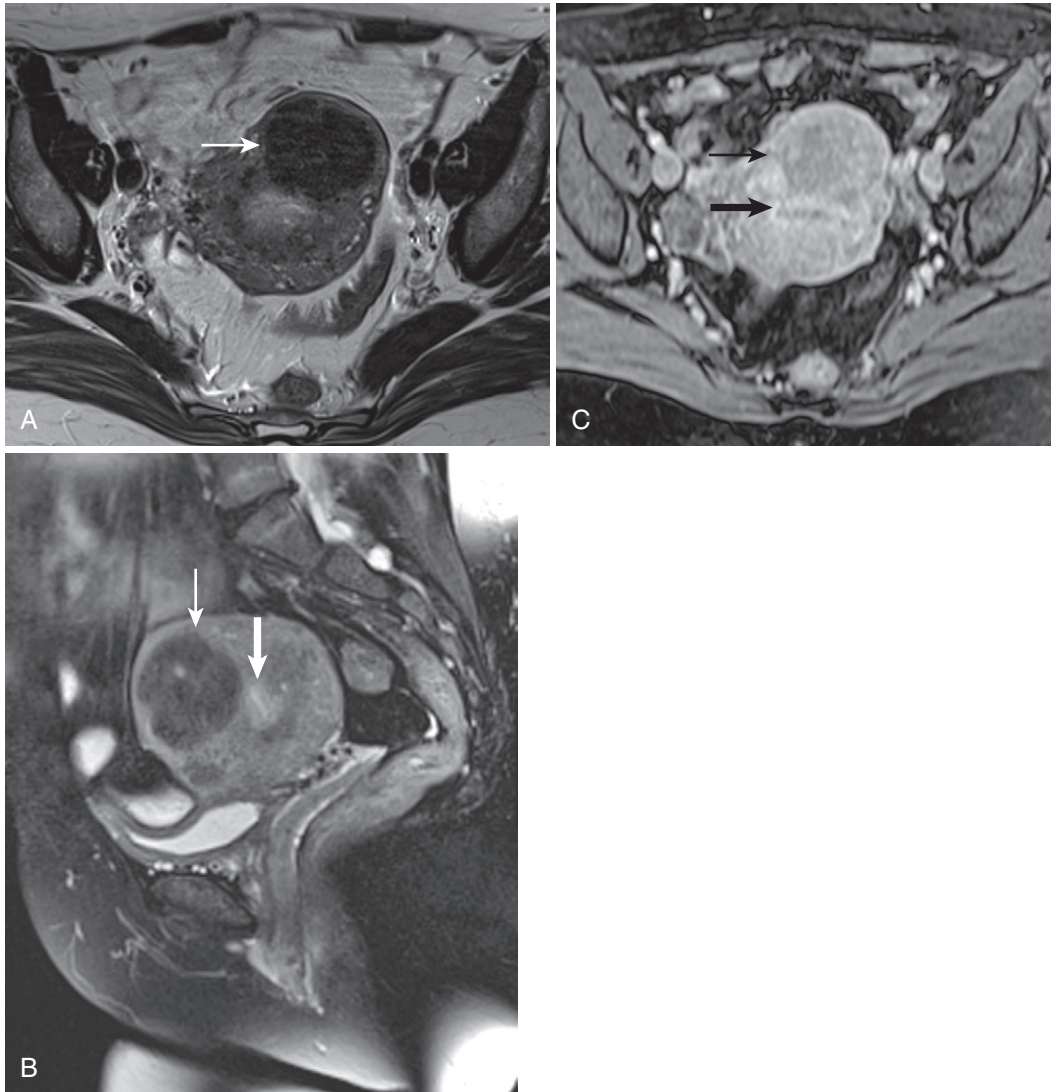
Intramural fibroid. The myometrium completely contains the hypointense, hypovascular fibroid (*thin arrow* in A-C) seen to be distinct from the endometrium (*thick arrow* in B and C) on axial T2-weighted (A), sagittal T2-weighted fat-saturated (B), and axial enhanced T1-weighted fat-saturated gradient echo (C) images.
